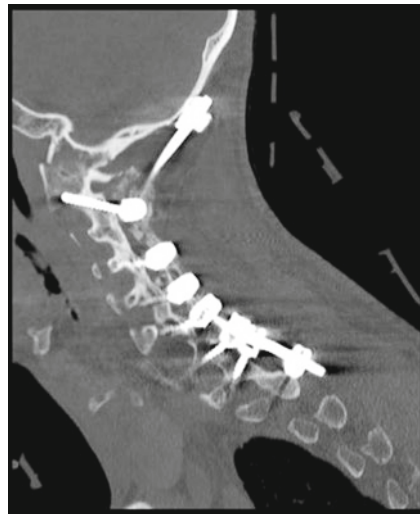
Sagittal CT following stabilization of the craniocervical instability using occipital fixation
